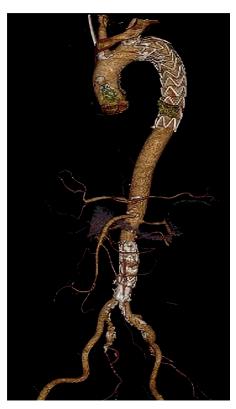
Postoperative computed tomography angiography (CTA) reconstruction image
